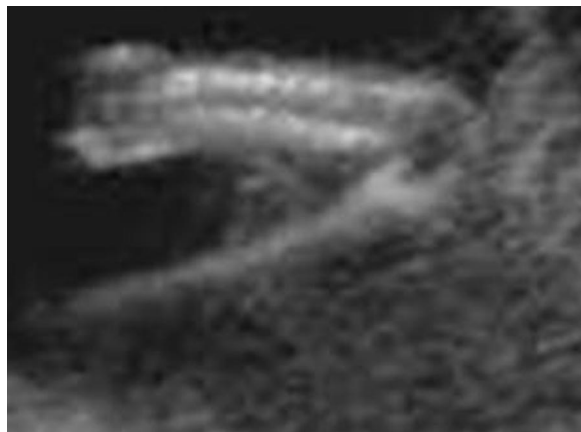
Congenital constriction band sequence. (a) US image of a fetus at 18 weeks of gestation shows constrictive rings (arrows) of the right forearm, with distal soft-tissue edema. (b) Corresponding fetal radiograph helps confirm the presence of a constrictive ring of the right forearm and shows distal amputation and syndactyly on the left side.
